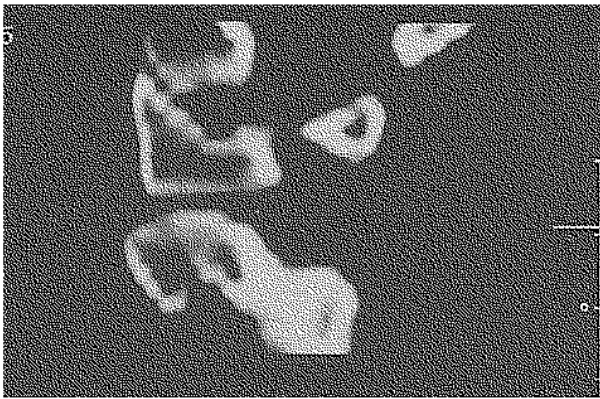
Sagittal CT reconstruction made 3 months after trauma.
